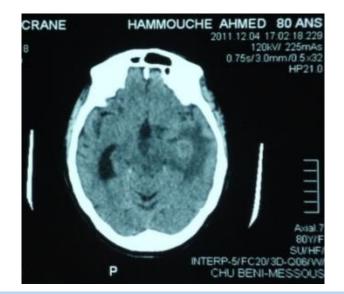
CT image of a deep tumor nodule
